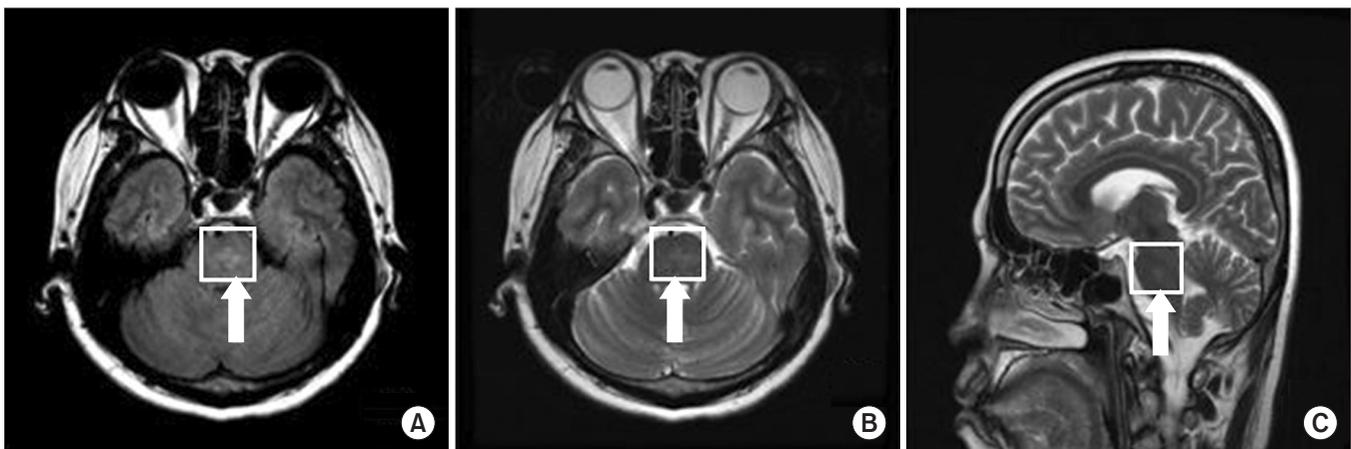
Brain magnetic resonance imaging (MRI) scan at the level of the pons: T2 FLAIR image (A), T2-weighted image (B), and T2-weighted sagittal image (C). MRI scan demonstrates an ill-defined, patchy, trident-shaped, mild high signal intensity lesion in the pons (arrow). Otherwise, no significant focal lesions were noted.
